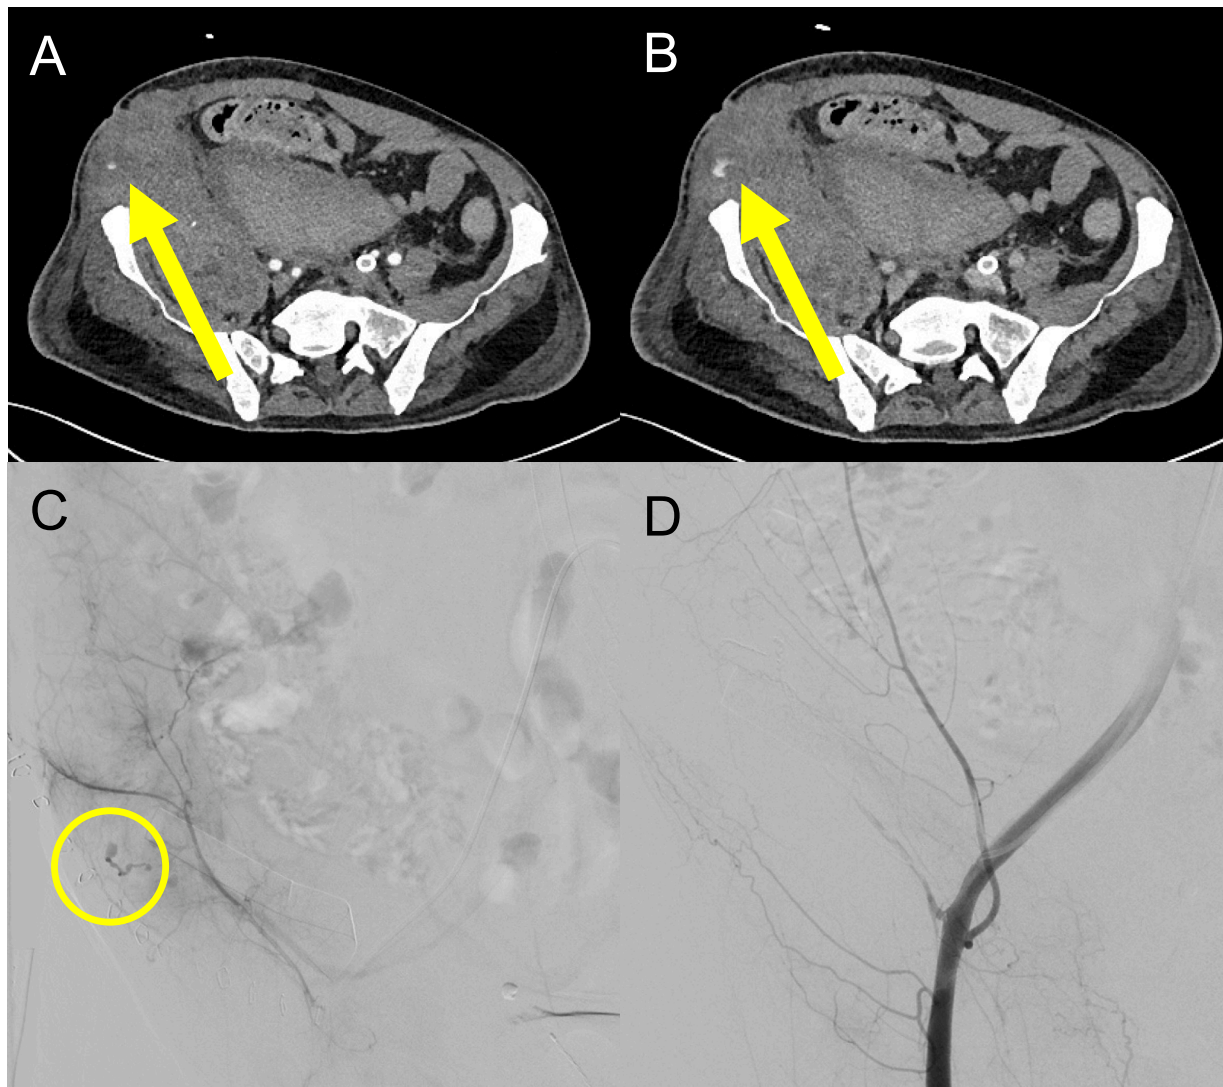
A 66-year-old male patient with COVID-19 infection necessitating ECMO treatment developed a multifocal, active arterial bleeding from the right deep circumflex iliac artery with a large hematoma in the CT in the arterial (A) and porto-venous phase (B). (C) In the angiography, extravasation of contrast media from the deep circumflex iliac artery could be seen and endovascular treatment was performed. The deep circumflex iliac artery was occluded with coils and glue to stop the bleeding. (D) In the control series, no extravasation of contrast media could be detected.
